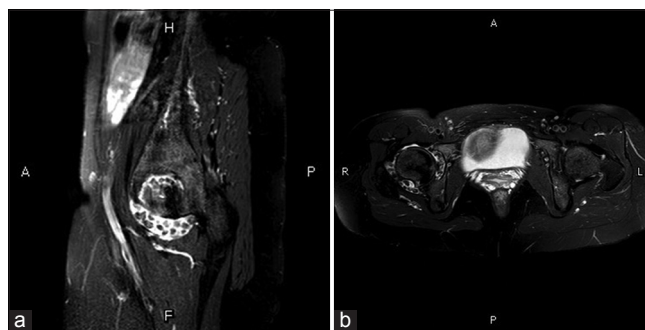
(a and b) Magnetic resonance imaging showed proliferation of the synovium within the joint space without obvious invasion to the acetabulum
